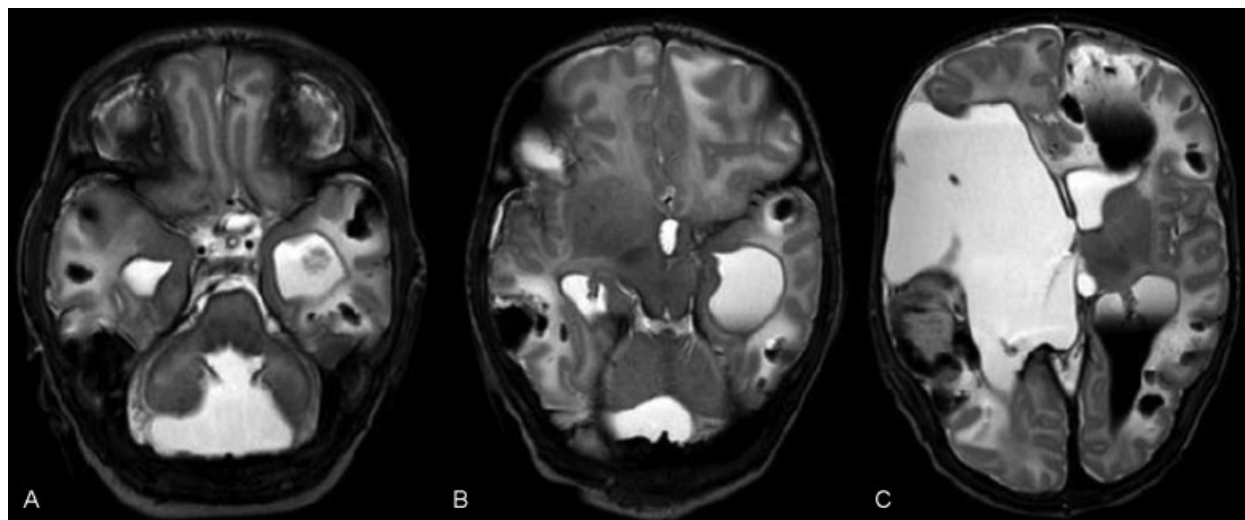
(a–c) MRI performed at week 7 of life. T2-weighted transverse images: (a) hypoplasia and dysplasia of the cerebellum, ventricular dilatation. (b) Dysplastic cerebellum, right-sided polymicrogyria (PMG). (c) Large porencephalic cyst on the right, PMG in the left parietal region. All images show in addition multiple hemorrhages.
